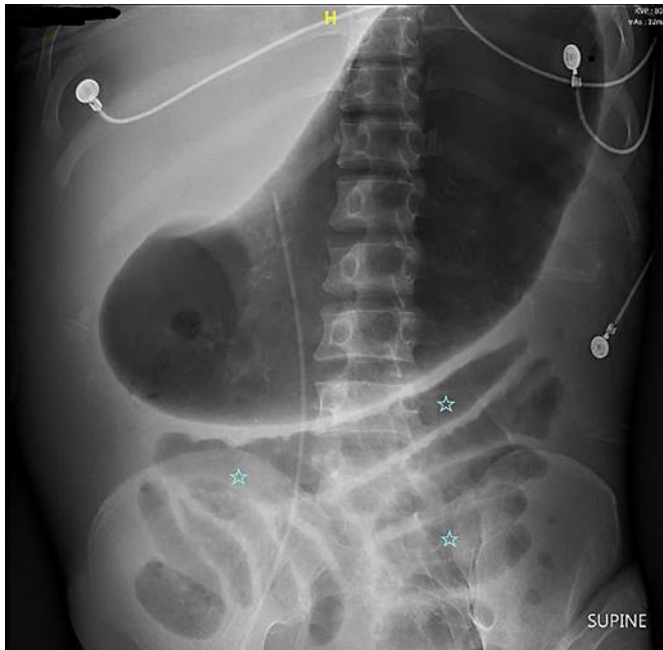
Supine abdominal X-ray demonstrating gaseous distention of the stomach. Air is also noted within the small intestine (asterisks).
